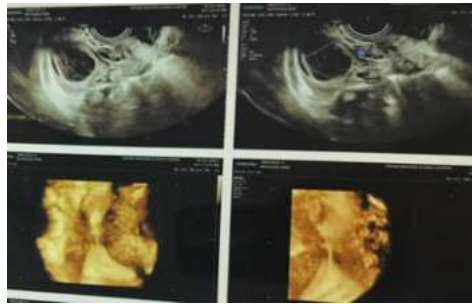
Radiographic, Ultrasound and MRI Presentation
